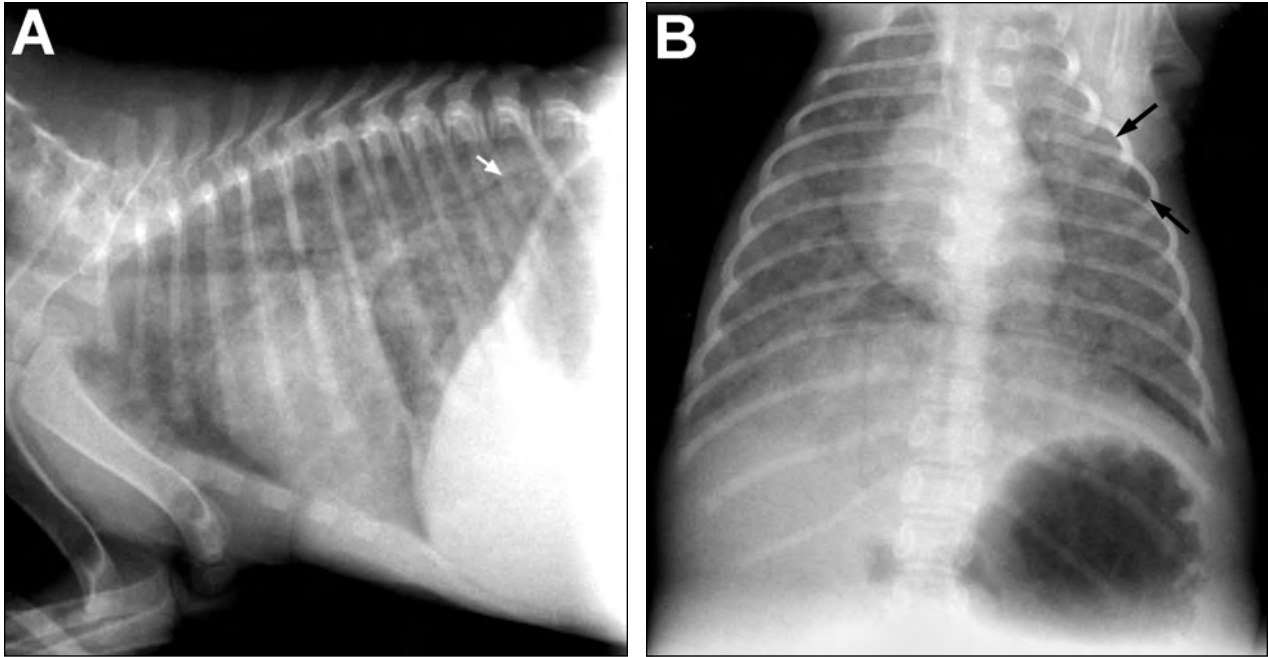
Same radiographic views as in Figure 1. Notice a severe diffuse increase in soft tissue opacity throughout the pulmonary parenchyma almost completely obscuring the pulmonary vasculature. Air bronchograms (white arrow) are evident in the caudodorsal lung field. The peripheral aspect of the cranial segment of the left cranial lung lobe (black arrows) is not as severely affected as the remainder of the lung.
